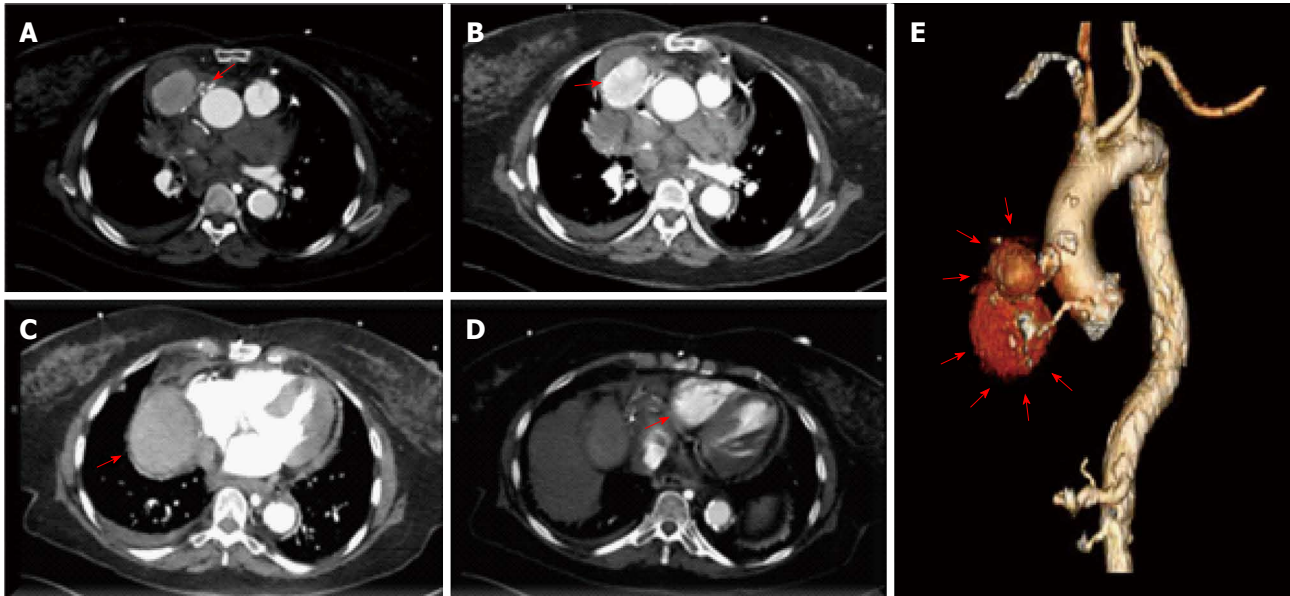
Transaxial tomographic views showing the right coronary artery origin and the saphenous vein grafts pseudoaneurysm lobes. A: The more cranial lobe of the pseudoaneurysm measured 4.7 cm × 5.4 cm in diameter and demonstrated mural thrombosis; B: The caudal lobe of the pseudoaneurysm also demonstrated mural thrombosis and measured 8 cm × 7 cm in its larger diameter; C, D: The caudal lobe of the giant pseudoaneurysm was patent and demonstrated flow into the distal right coronary and right posterior descending artery; E: Computed tomographic 3-D reconstruction of the saphenous vein grafts giant bilobed pseudoaneurysm to the right posterior descending artery.
